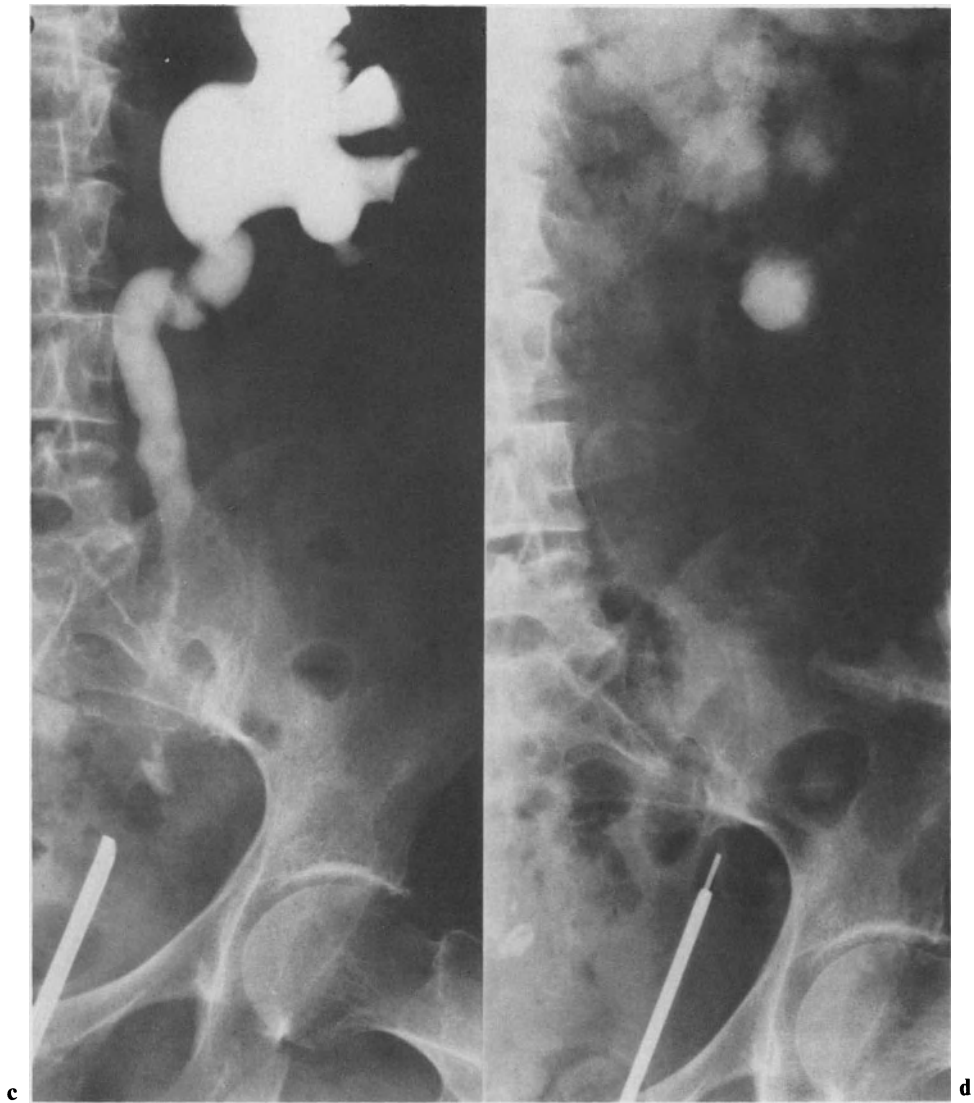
Ureteroscope in place. d Ureteroscope with ultrasound probe in place after complete disintegration of ureteral stone
